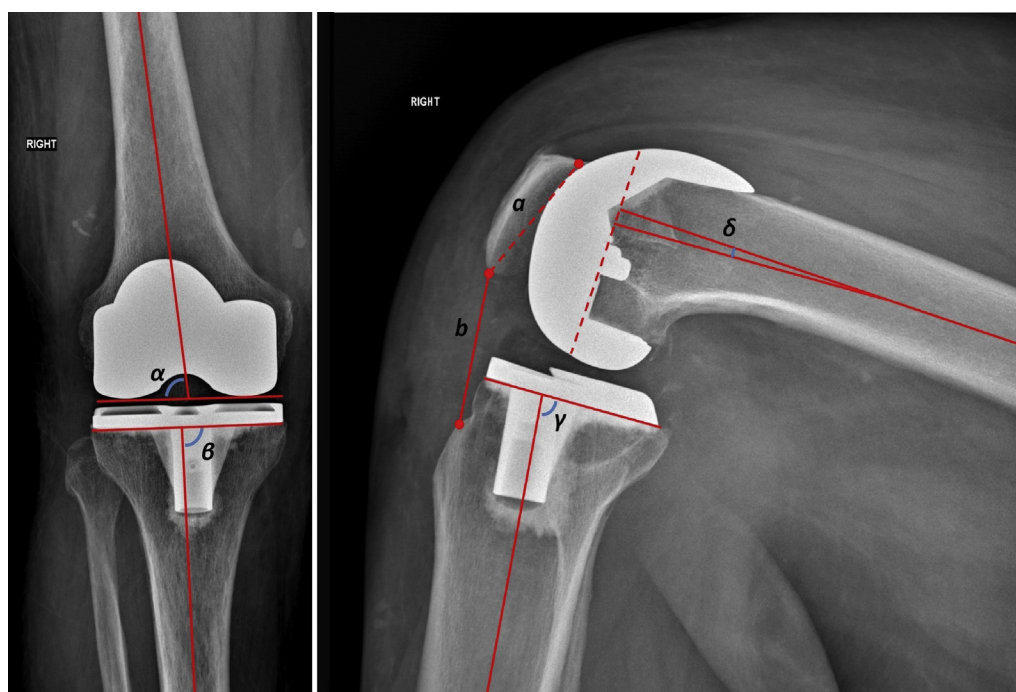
Postoperative radiological measurements on knee anteroposterior (AP) view (left x-ray) and lateral view (right x-ray).
